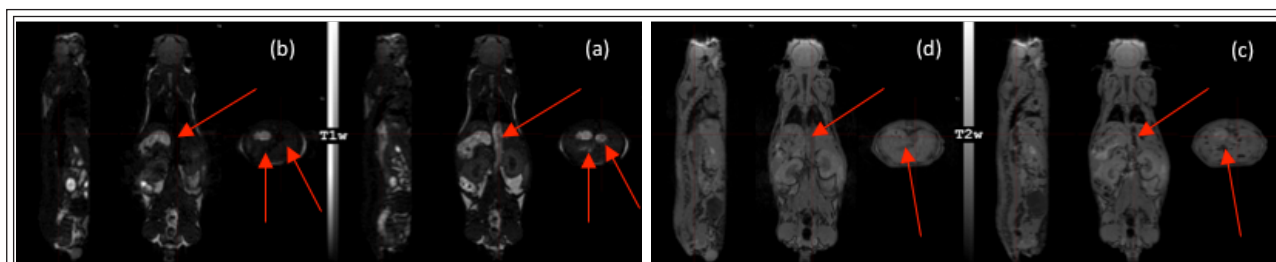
The PBNP_AC-HCl 1:2 pre (a, c) and post (b, d) injection, on T1 and T2-weighted images. Images (a) and (b) show hyperintense changes in the abdominal aorta and gastrointestinal tract; images (c) and (d) support the information of T1w images; the vascular system appears hypointense.
